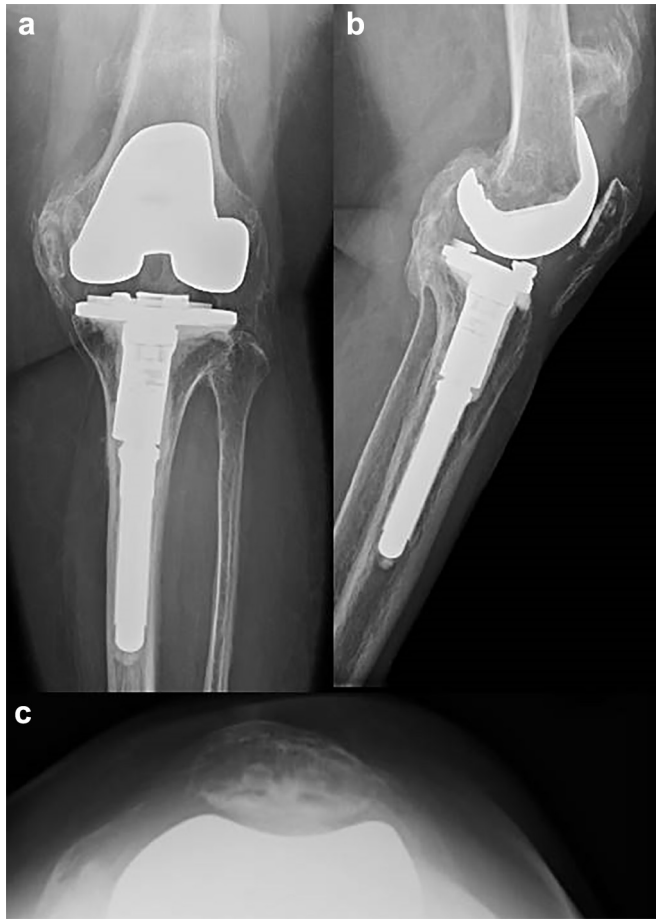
Preoperative radiographs (anteroposterior (AP) (a), lateral (b), and Merchant (c) views) showing extensive heterotopic ossification of the left total knee arthroplasty.
